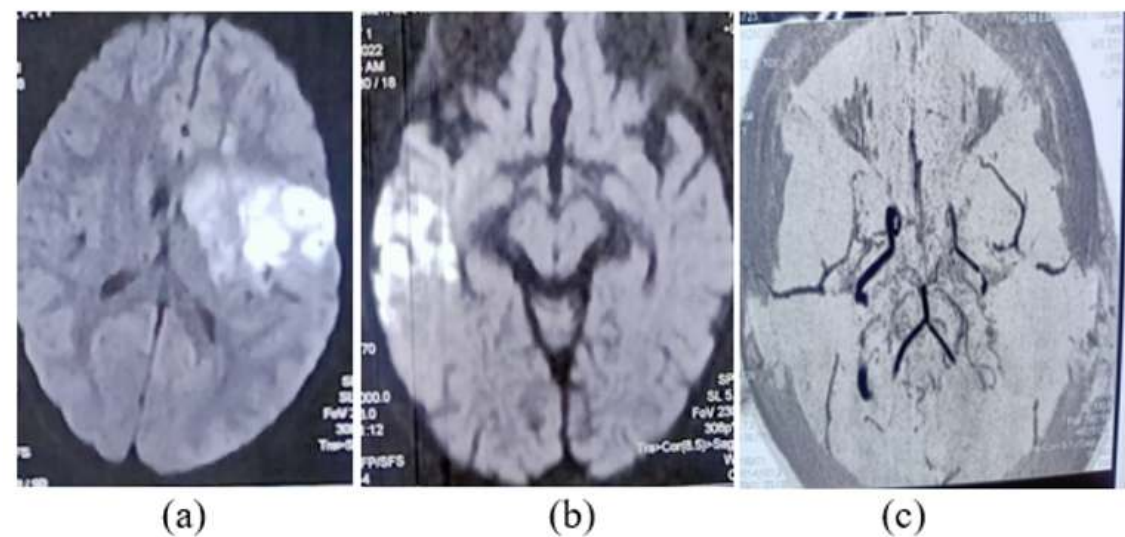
MRI image of Moyamoya disease showing- a) diffusion restriction in left parietal region, b) diffusion restriction in right temporal region and c) susceptibility weighted image – multiple bilateral collaterals around circle of Willis
